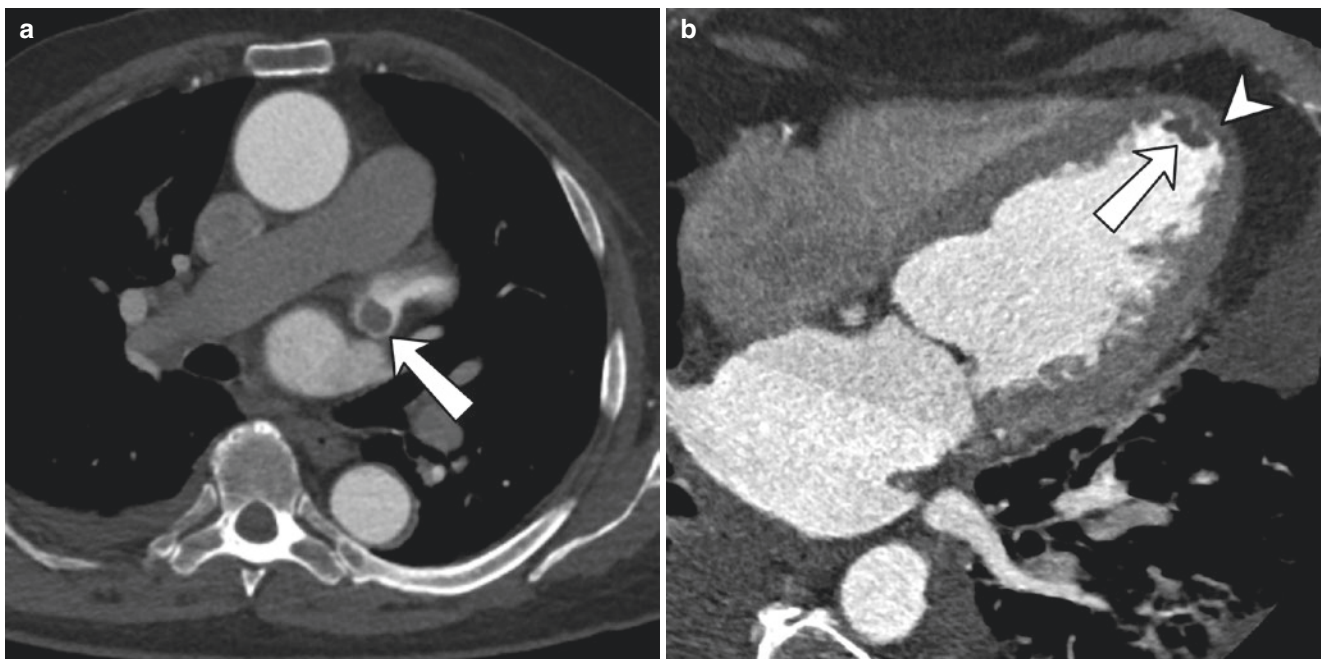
Coumadin ridge. Axial CT scan shows a prominent ridge between the left superior pulmonary vein and the body of the left atrium, which is consistent with a Coumadin ridge (arrow)
